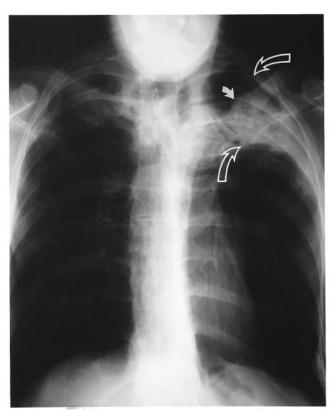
Frontal chest radiograph of a 49-yr-old male demonstrates left apical fibrosis with a 6 cm cavity (large curved arrows). Within the cavity there is a mycetoma (small curved arrow).
